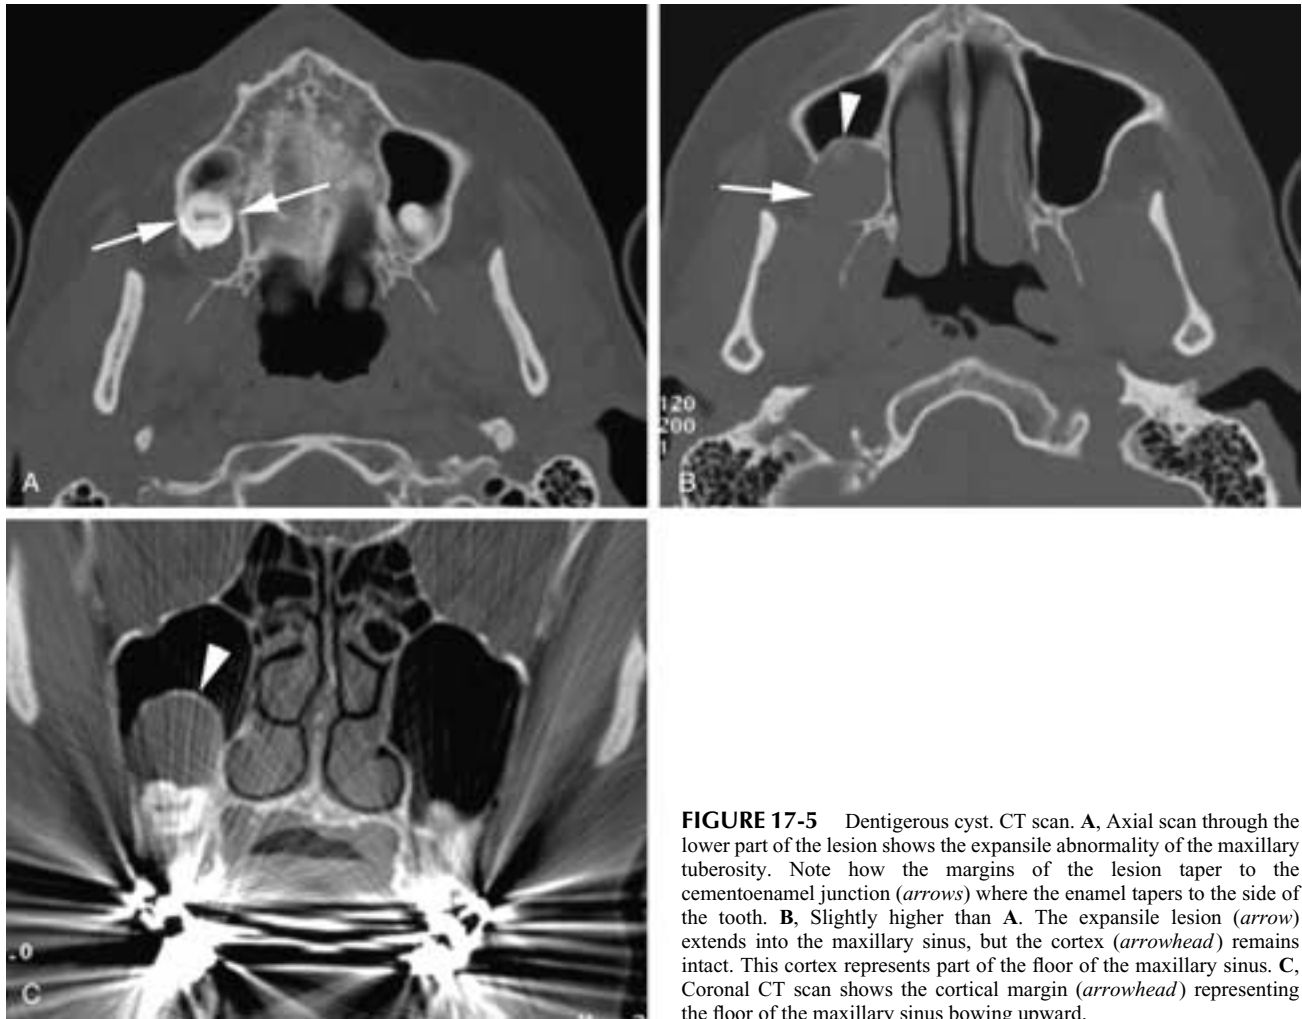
Dentigerous cyst. CT scan. A, Axial scan through the lower part of the lesion shows the expansile abnormality of the maxillary tuberosity. Note how the margins of the lesion taper to the cementoenamel junction (*arrows*) where the enamel tapers to the side of the tooth. B, Slightly higher than A. The expansile lesion (*arrow*) extends into the maxillary sinus, but the cortex (*arrowhead*) remains intact. This cortex represents part of the floor of the maxillary sinus. C, Coronal CT scan shows the cortical margin (*arrowhead*) representing the floor of the maxillary sinus bowing upward.
